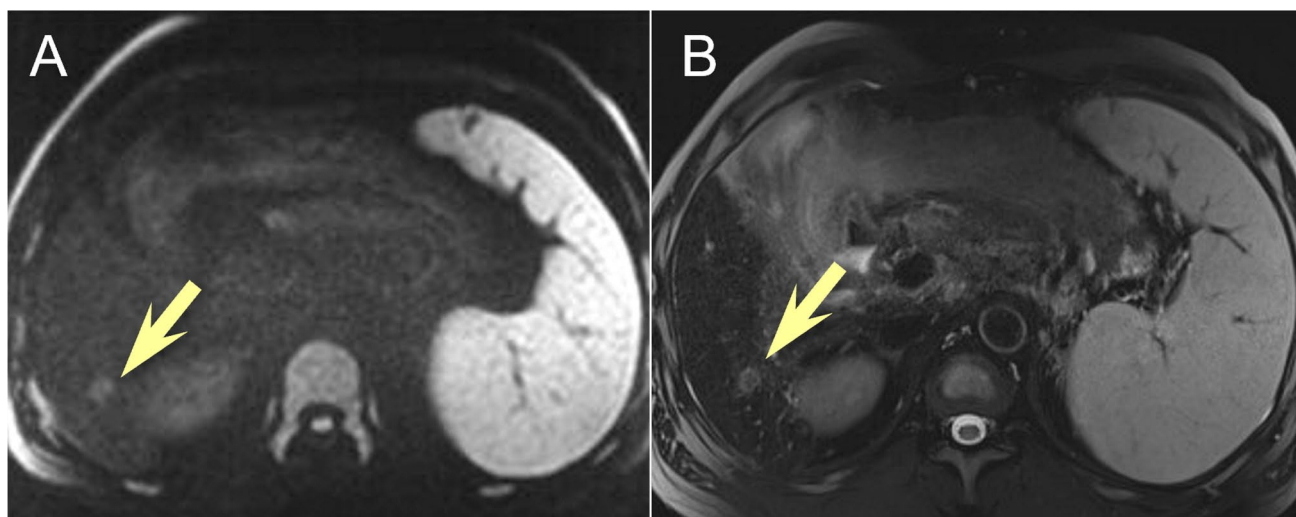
Positive non-enhanced abbreviated magnetic resonance imaging (NE-AMRI). A 49-year-old man with alcoholic liver cirrhosis. The diffusion-weighted (A, b -value = 900 s/mm²) and T2-weighted
